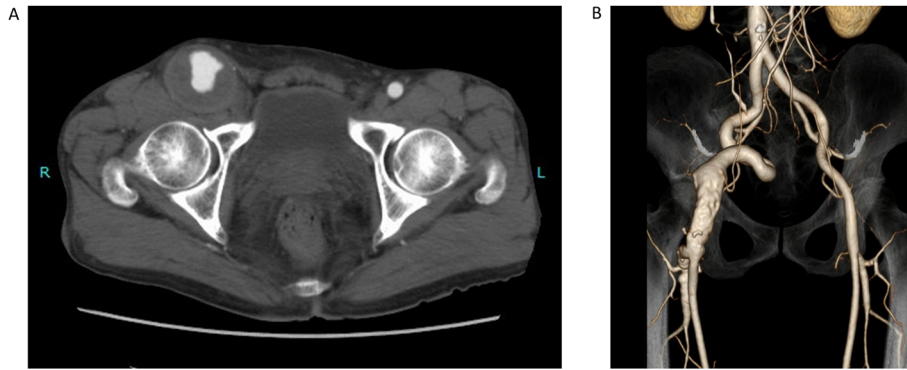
Preoperative computed tomography showing a right iliofemoral aneurysm. (A) Axial image, (B) 3D image.
